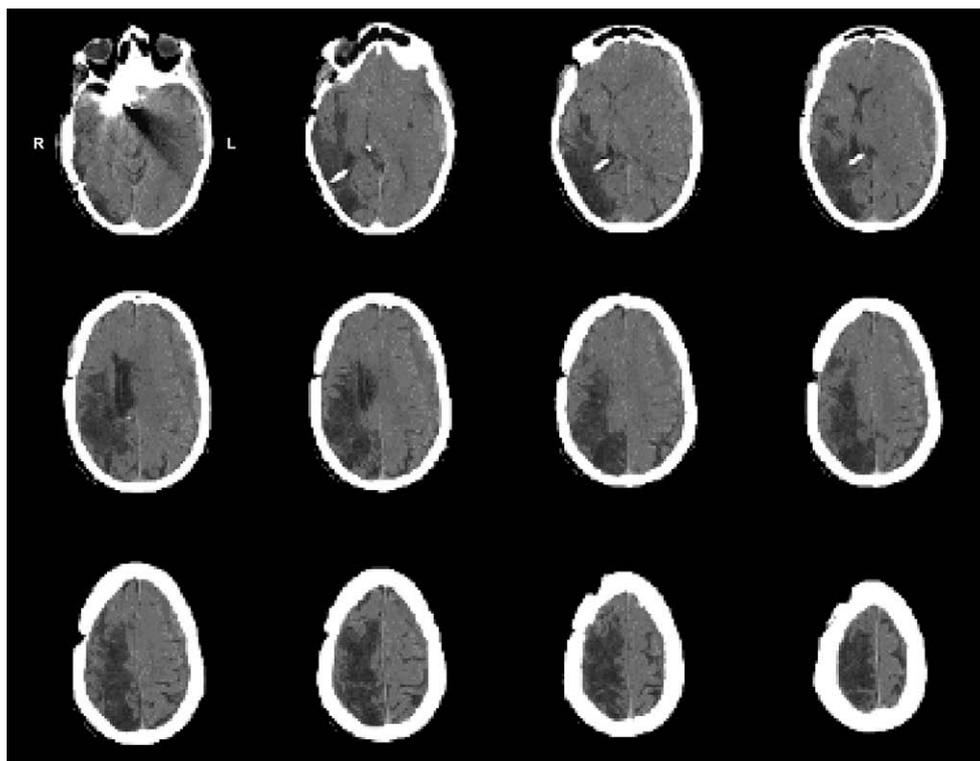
CT scan (2005) showing the clip and the large infarction of the right hemisphere and the SDH in the left hemisphere.
